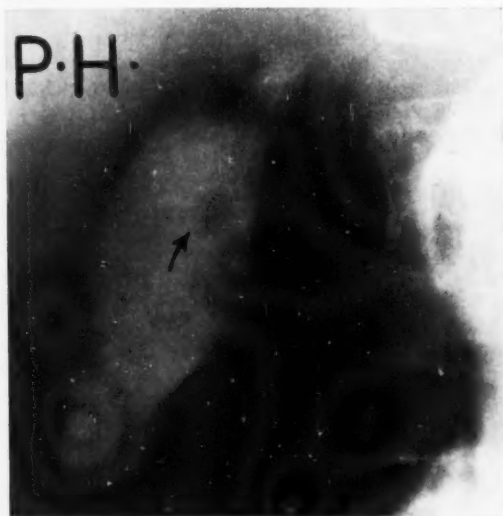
Roentgenogram showing a solitary defect in the mid-portion of the body, seen *en face*, and constant in site no matter in what position the patient was examined. Although its site was atypical, the fact that it was solitary suggested the possibility of a *papilloma*. This diagnosis was finally established pathologically.
